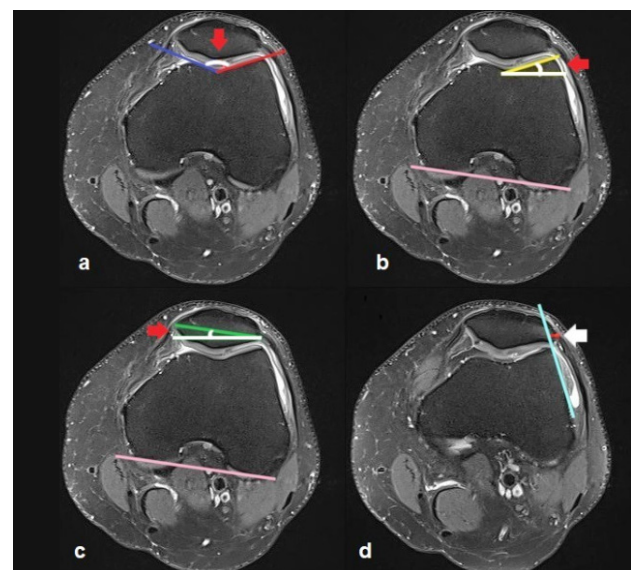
Axial magnetic resonance images shows; (a) Sulcus angle: The angle (red arrow) between the medial femoral condyle (blue line) and the lateral femoral condyle lines (red line), (b): Lateral trochlear
